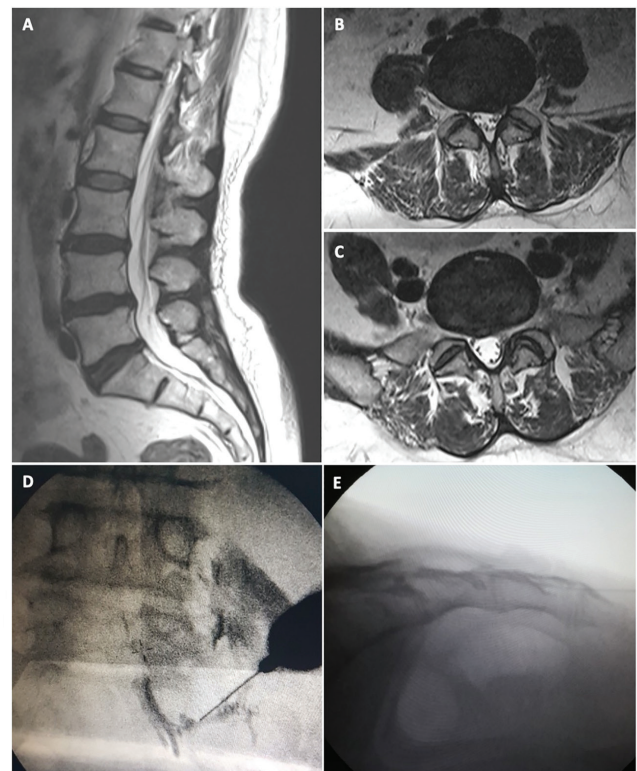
A-C) Pre-injection magnetic resonance imaging. Axial and sagittal sections show multi-level lumbar disc disease. D) Transforaminal epidural steroid injection. E) Caudal epidural steroid injection
